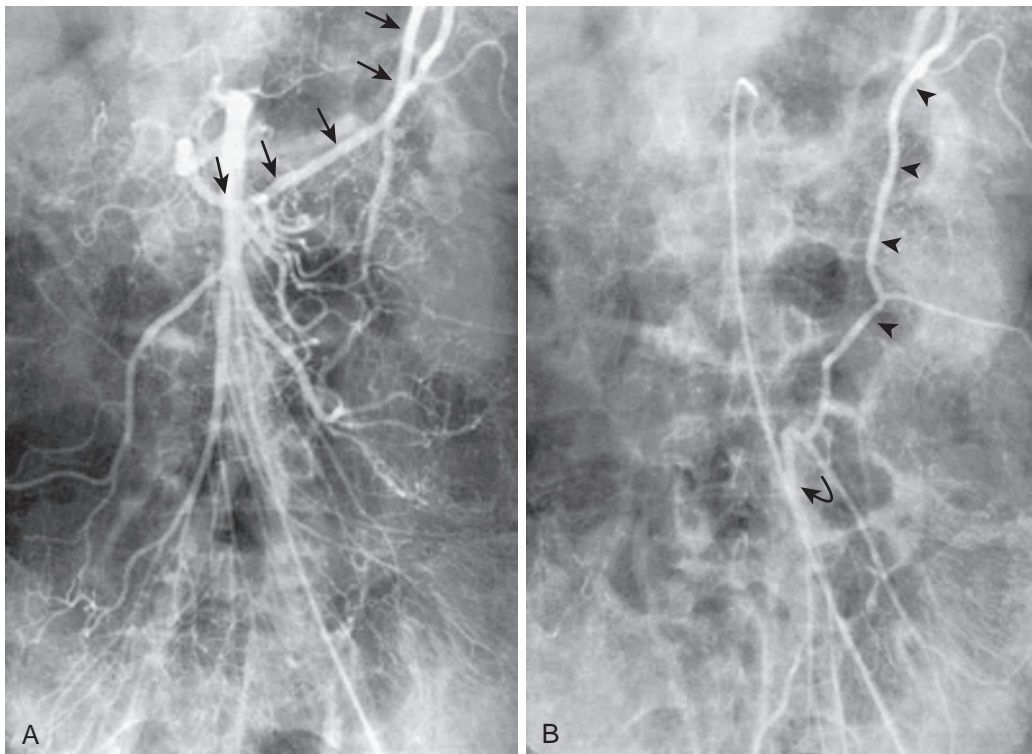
Collateral blood supply of the colon. Early (A) and delayed (B) radiographs from a superior mesenteric arteriogram demonstrate an enlarged marginal artery arising from the middle colic in A (arrows). B. The marginal artery fills the left colic artery (arrowheads) in a retrograde fashion, allowing reconstitution of the inferior mesenteric trunk (curved arrow). The dilated, tortuous collateral pathway has been called a meandering mesenteric artery.
